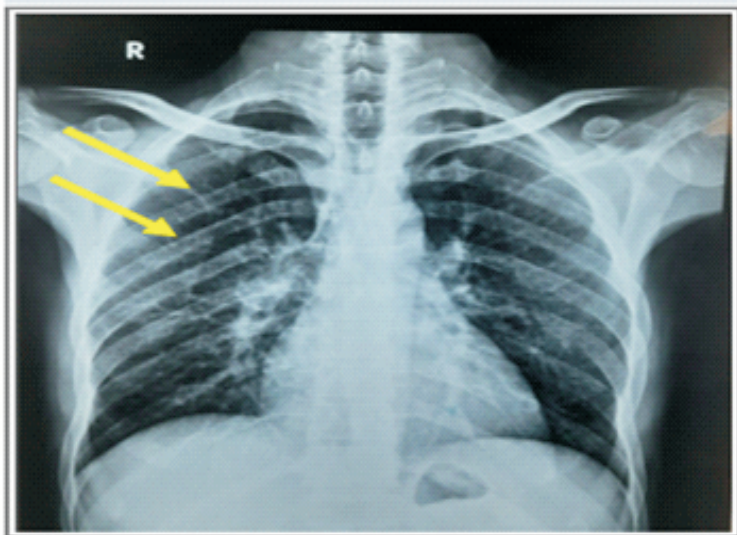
X-ray chest showed right hilar lymphadenopathy (yellow arrows)
